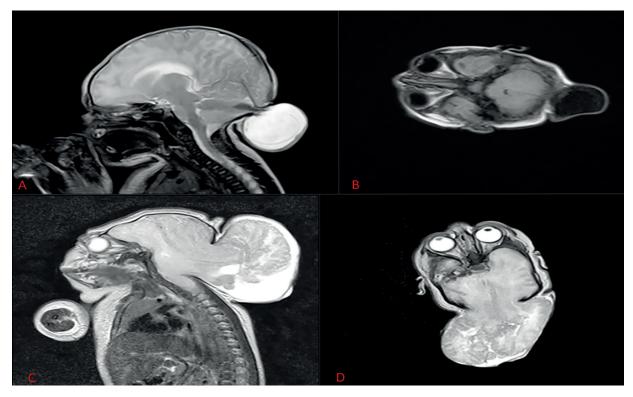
A, B, MRI sagittal and axial view of occipital meningocele. C, D, MRI sagittal and axial view of occipital encephalocele with Chiari type 3 malformation.
